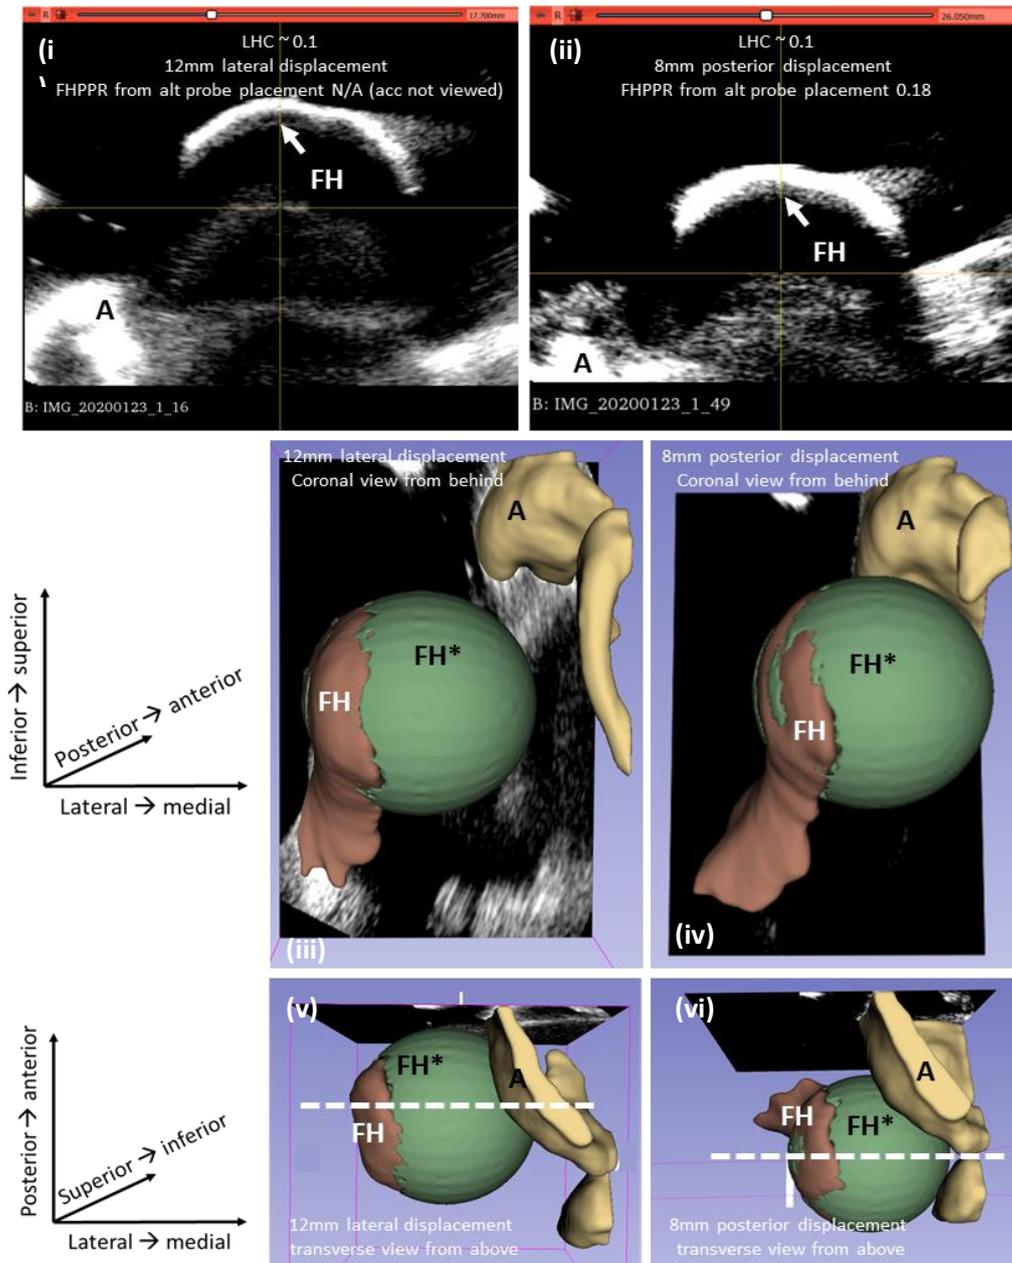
Further exploration of two image volumes where the LHC measurement was similar. (i & ii) - the ultrasound slices selected for LHC measurement. (iii & iv) - the coronal views (from behind) of the rendered hips. (v & vi) - transverse view of the rendered hip, with the position of the slice selected for analysis marked highlighted. A = acetabulum render, FH = femoral head render, \*FH = spherical estimate of femoral head.
